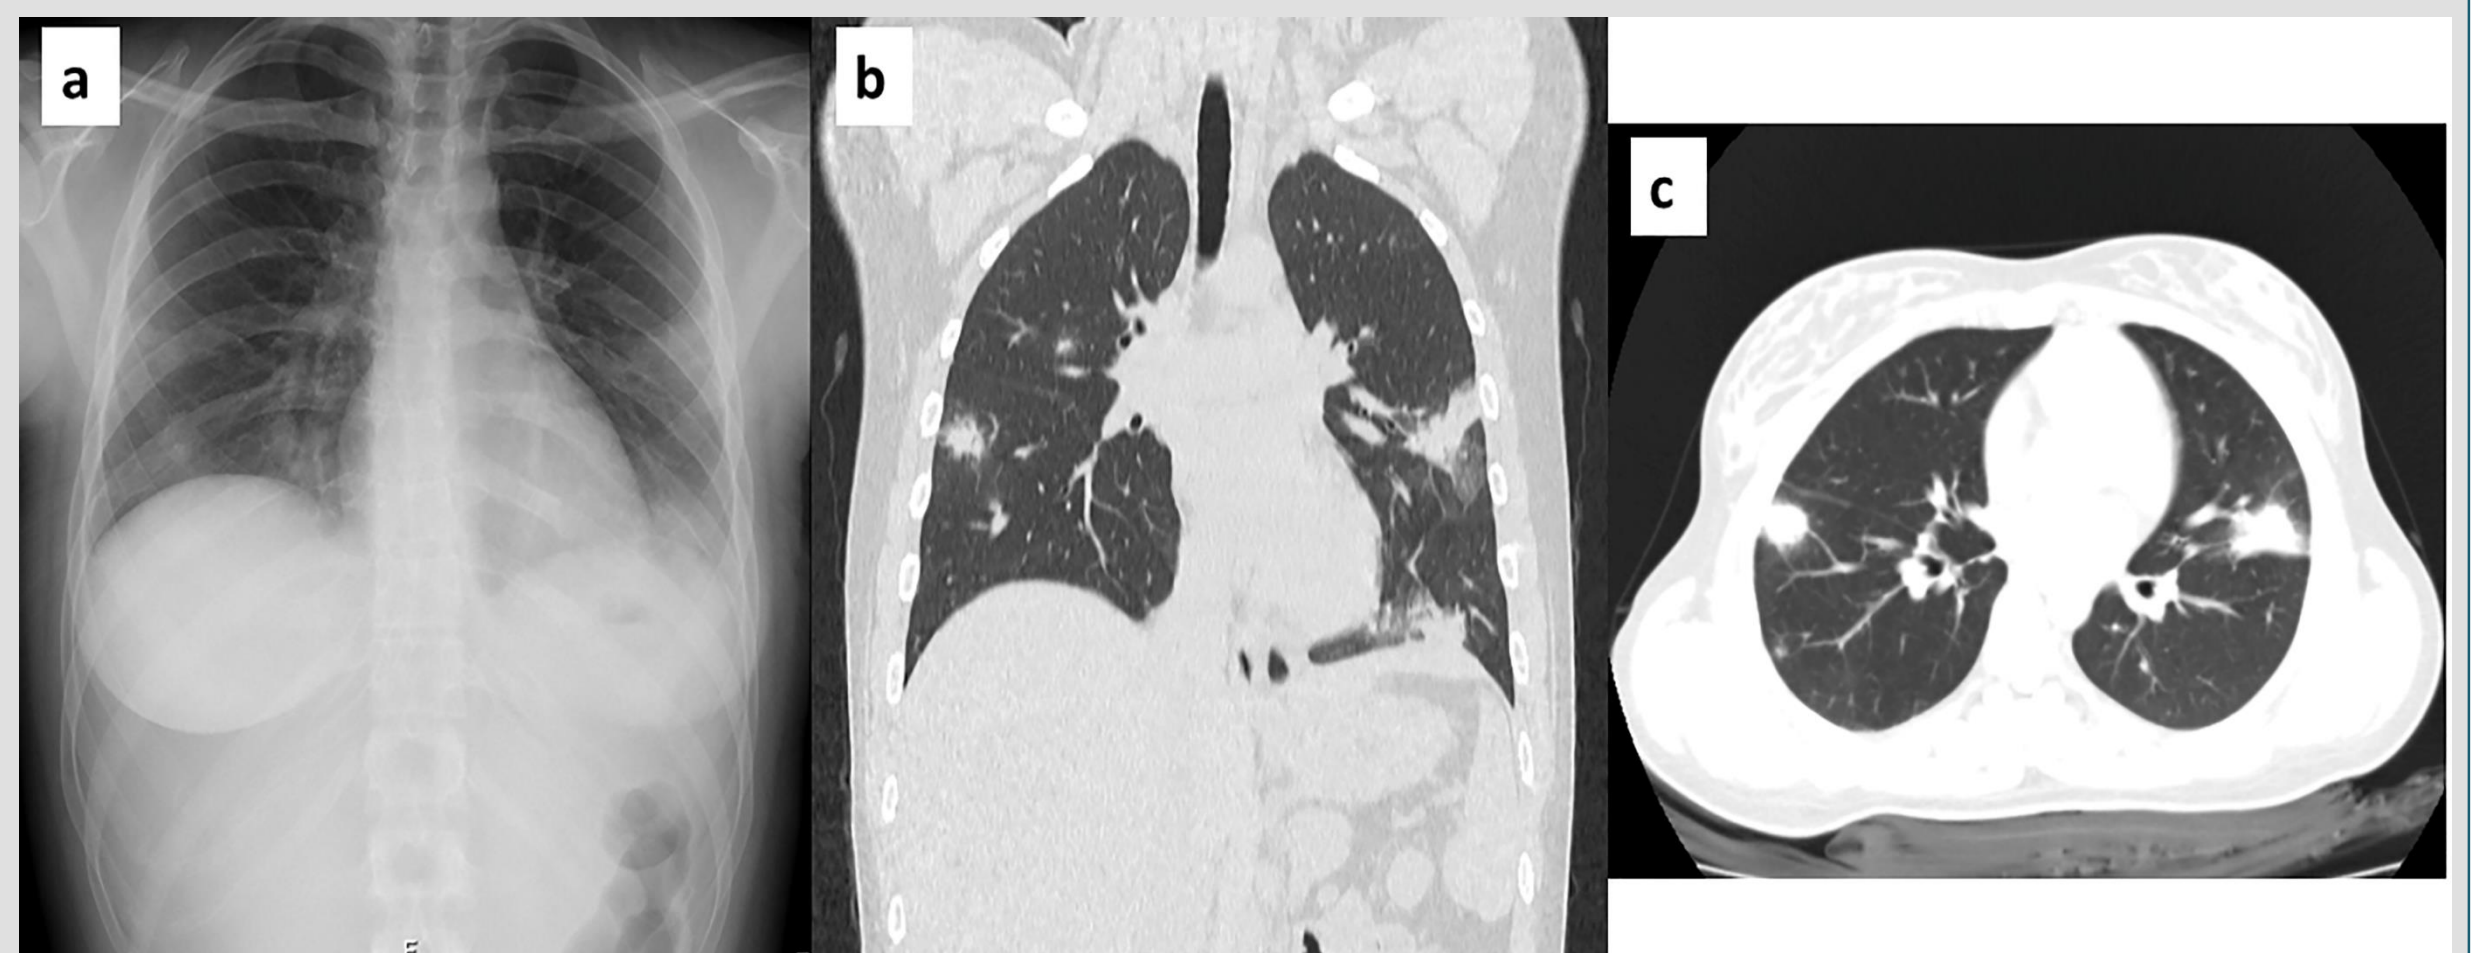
Thorax X-ray images showing patchy bilateral infiltrates (a). Thorax CT scan images in coronal (b) and axial (c) view revealing patchy bilateral consolidations and ground glass opacities in a subpleural distribution.
